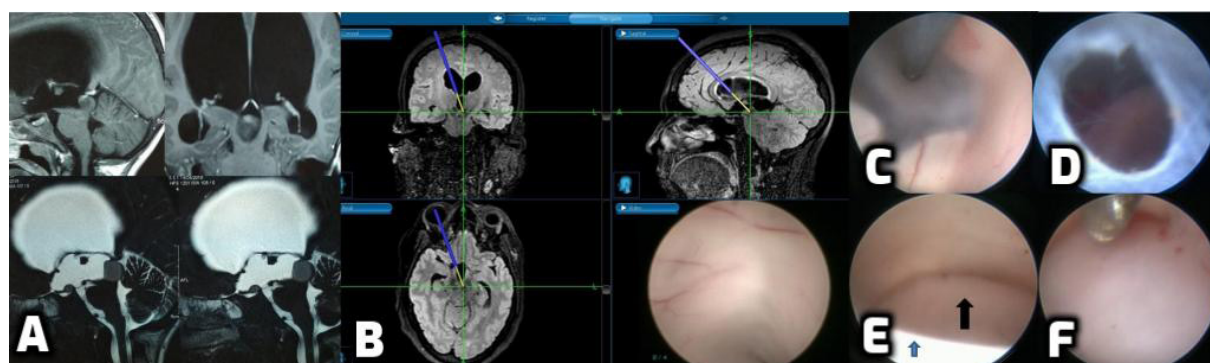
A: MRI (post contrast and T2WI) of a five-year-old child with pineal lesion and hydrocephalus; B: use of navigation to help in planning the trajectory intraoperatively; C: endoscopic third ventriculostomy done; D: basilar artery seen through the flapping ventriculostomy site; E: tumour (black arrow) seen anterior to the massa intermedia (blue arrow); F: the scope was negotiated below the massa intermedia to reach the tumour for biopsy
